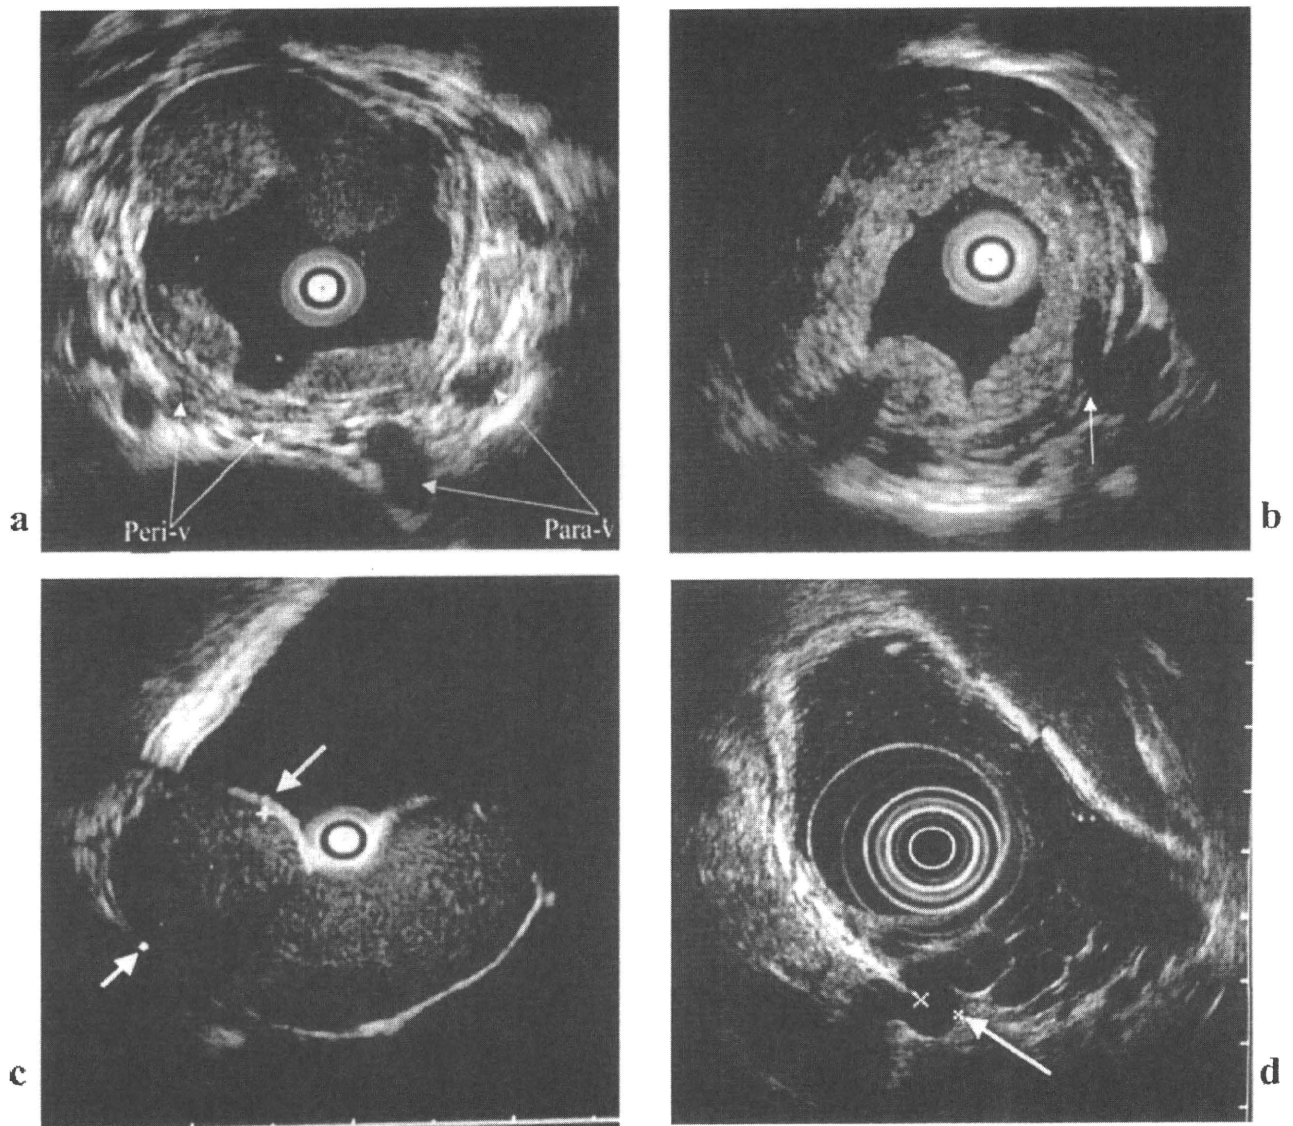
Endoscopic ultrasonography (EUS) images of esophageal varices: (a) peri-esophageal veins (Peri-v), para-esophageal veins (Para-v); (b) perforating vein (Pv) (arrow). EUS images of gastric varices: (c) using a 20-MHz probe (arrow: diameter of gastric varices), (d) using a 7.5-MHz probe (arrow: perforating vein).
